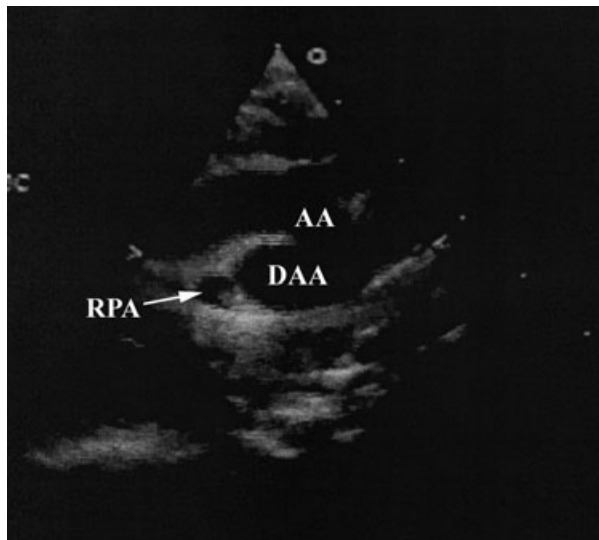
Transthoracic echocardiogram in the suprasternal view demonstrates the aortic arch with ductus arteriosus aneurysm. AA, aortic arch; DAA, ductal arteriosus aneurysm; RPA, right pulmonary artery.
